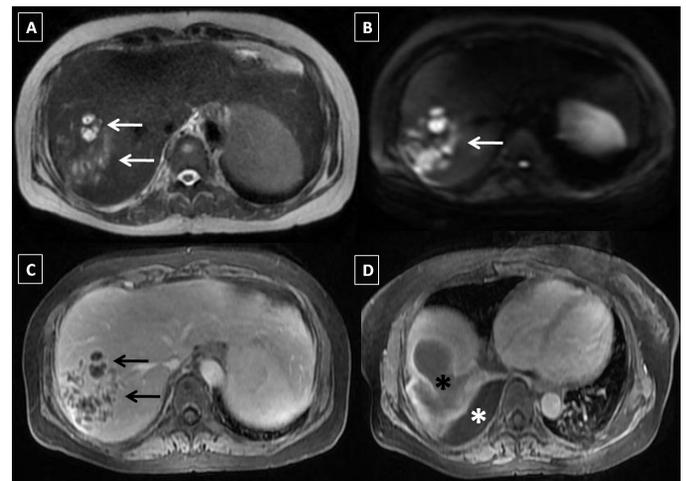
53-year old female with intermittent high grade fever. (A) Axial T2-weighted MR image shows conglomerate hyperintense cystic lesions (arrows) showing diffusion restriction (arrow in B). (C) Peripheral enhancement is seen in these lesions (arrows). (D) Subcapsular rupture of the lesions is seen (black asterisk) with right pleural effusion (white asterisk).
